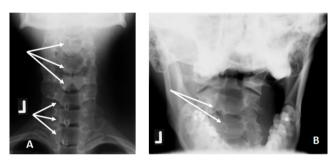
Case #1 Plain Film Radiographs. A. AP Cervical. Marked spinous process (SP) deviation to the left. B. APOM. Marked deviation of C2 spinous process to the left. (Arrows indicate SP deviation.)
